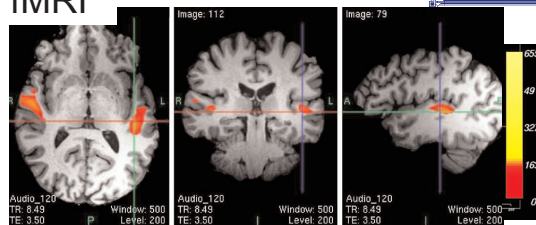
Patient #2's functional MRI localizations of the auditory cortex response to music.
